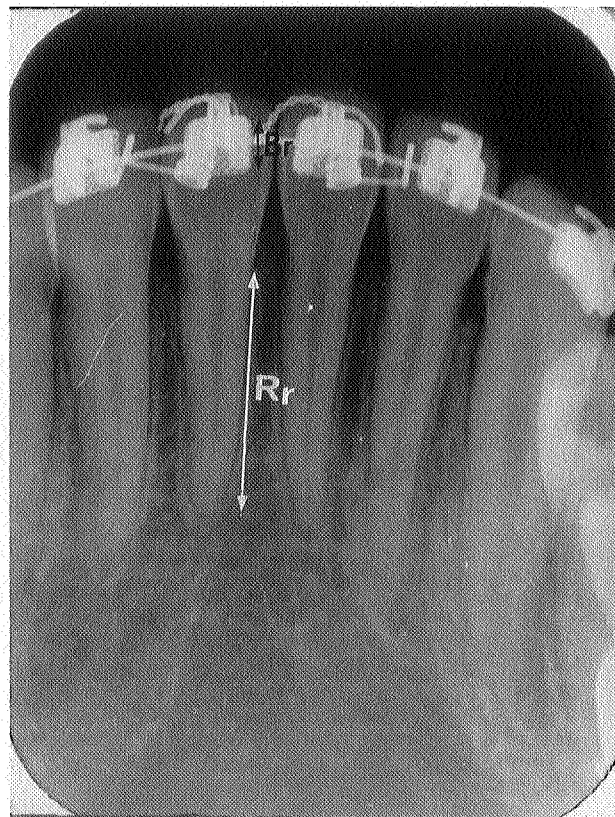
Periapical radiographs showing the measurement of radiographic root length (R_R) from the radiographic bracket length (B_R). See text for calculation of actual root length.
